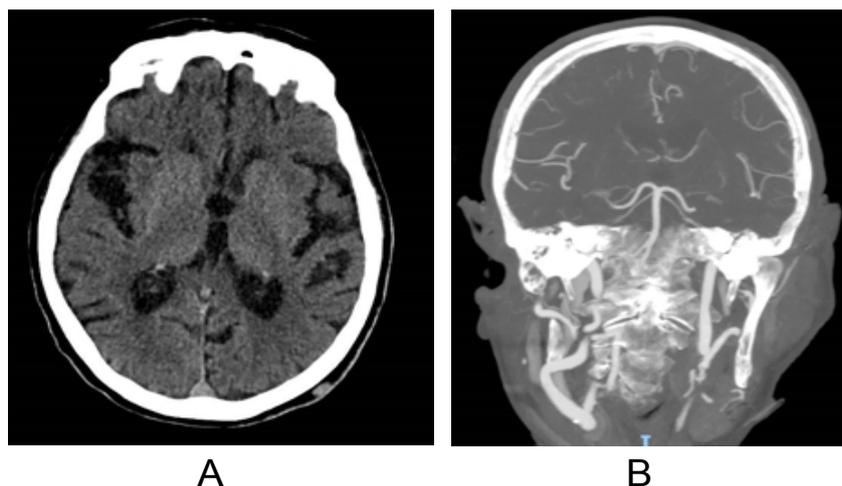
A normal non-contrast CT (A) and CT angiography (B).
